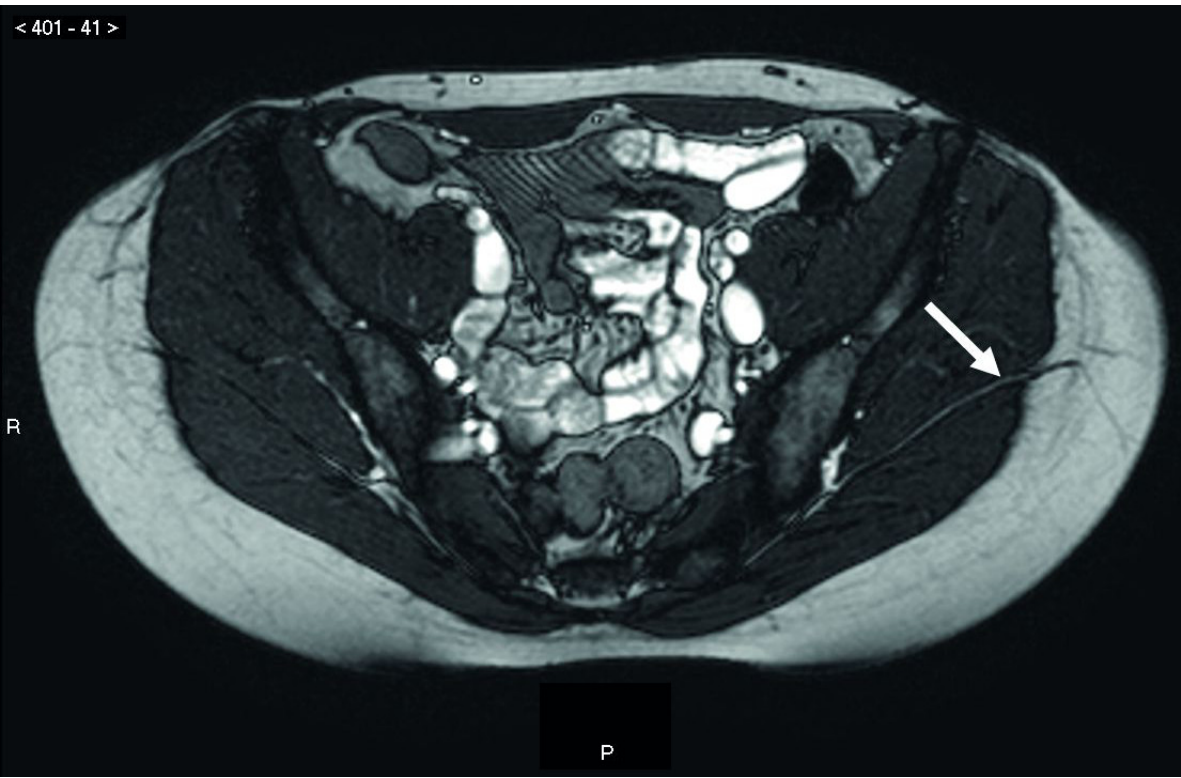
Transverse, balanced, T1-weighted FFE sequence on MRA. The arrow shows the perforator vein(s) running between gluteus maximus and medius muscle.
